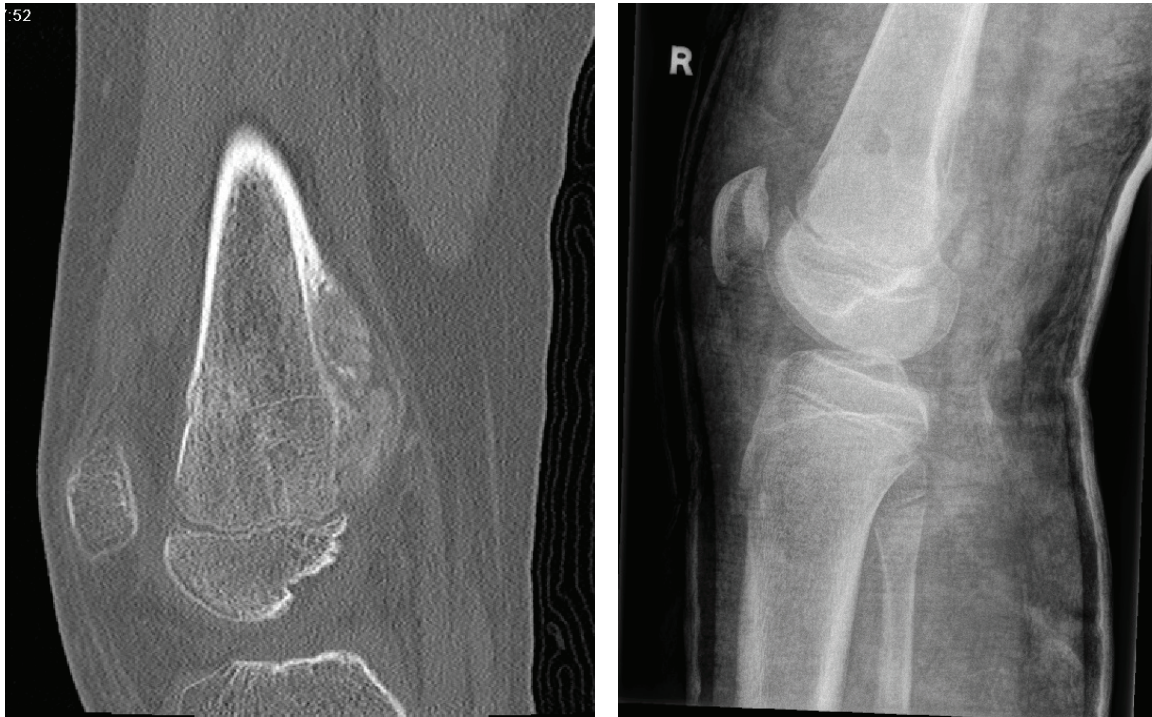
X-Ray of parosteal osteosarcoma in the distal femur (left) and the proximal tibia (right).
